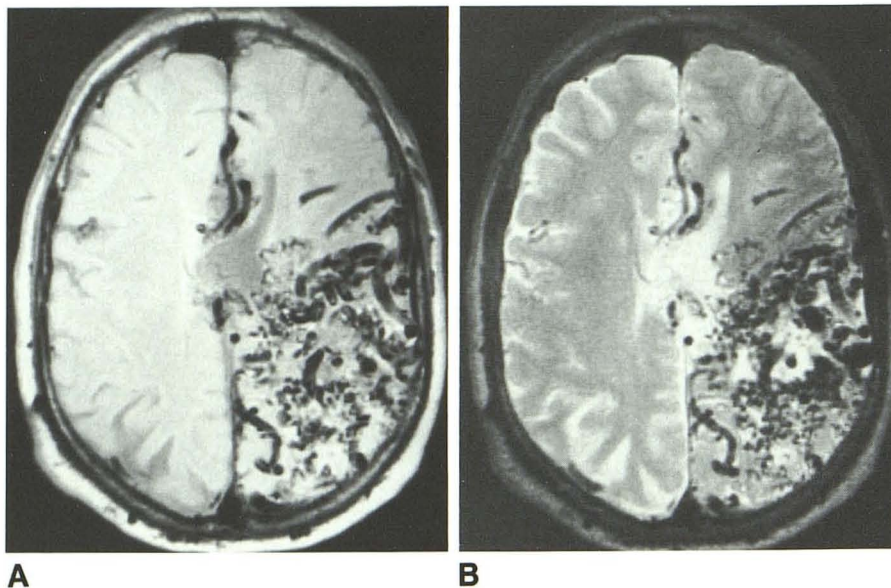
Axial MR image of large parietal lobe AVM that hemorrhaged 6 years earlier.
